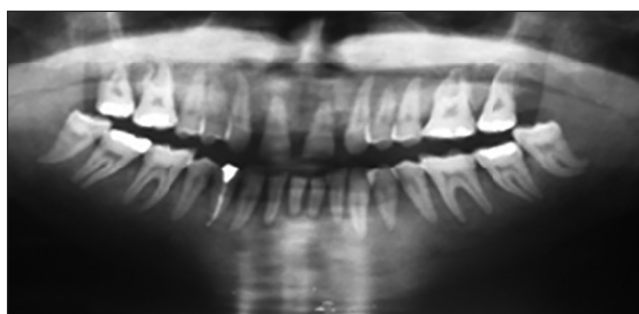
Panoramic radiograph, shows multiple small unilocular radioluscencies, suggestive of brown tumors
